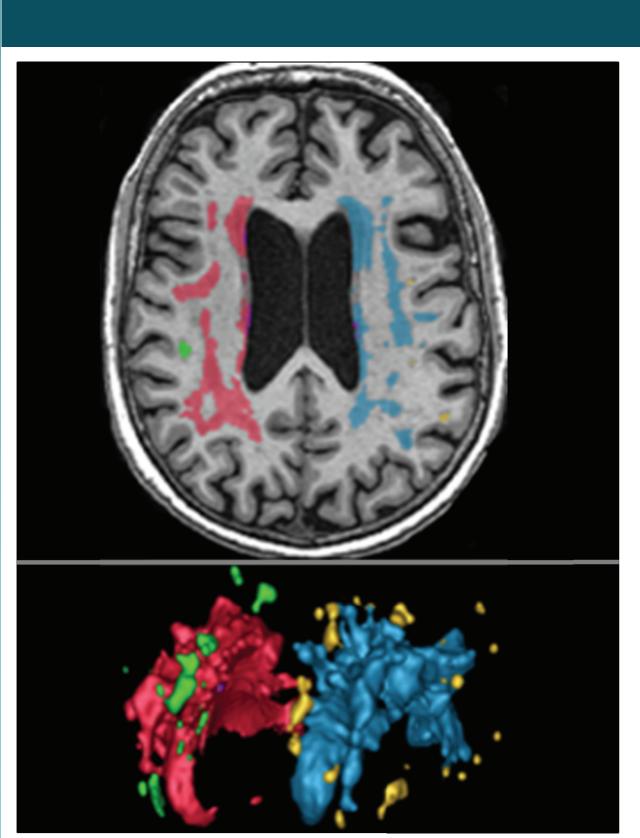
(Top) Axial T1-weighted MRI. (Bottom) 3-D rendering of WMH segmentation. Deep WMH shown in green & yellow, periventricular WMH shown in red & blue.
